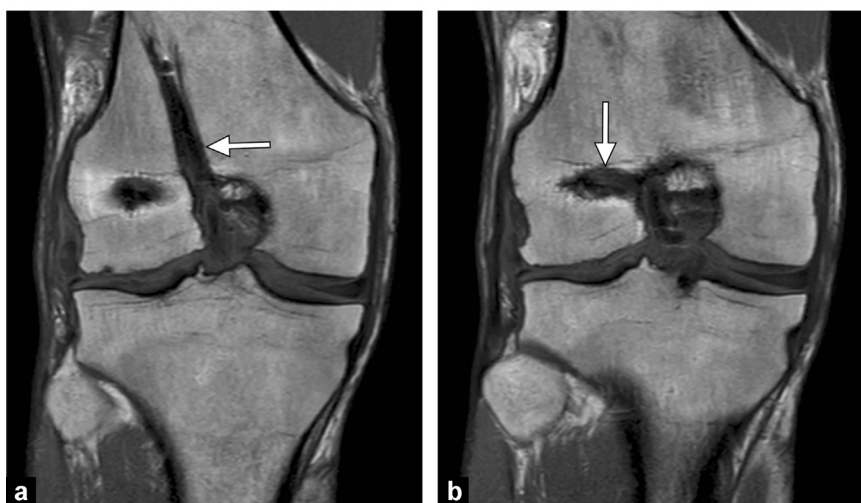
a and b: double-bundle reconstruction. T1-weighted coronal MR images. Note the presence of two femoral tunnels, oriented differently (arrows).
